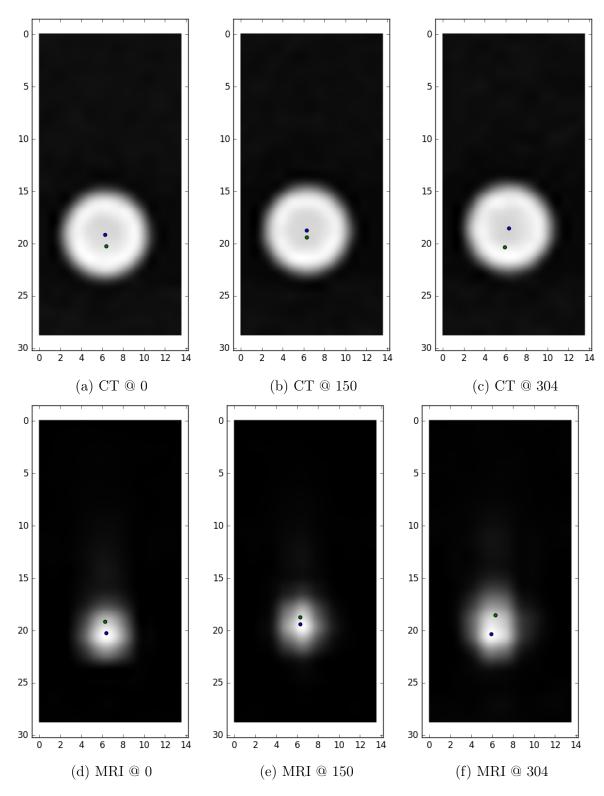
MRI x100; blue dot centroid MRI, green dot centroid CT (same scale); slice 150 is approximately at the isocentre, 0 on the very end of the image, 304 close to an air bubble
